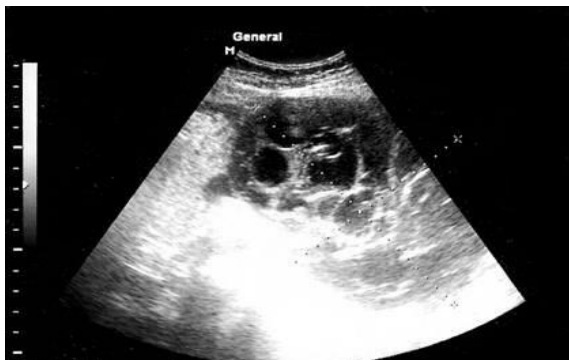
Ultrasonography; multilocular pancreatic tumor formation.
